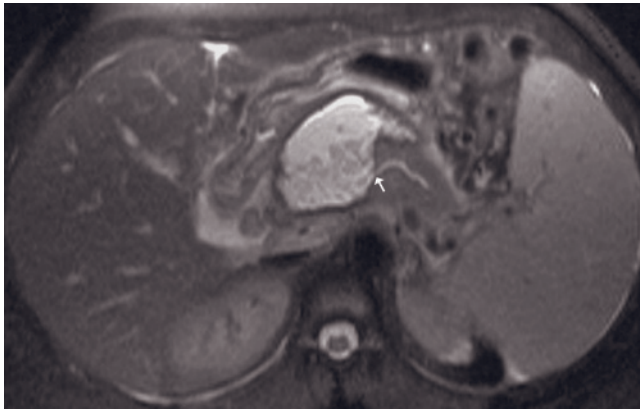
(Continued) An 8-cm pseudocyst is present in the region of the porta hepatis that is mildly high in signal intensity on T1-weighted images (*a, b*) and high in signal intensity on the T2-weighted image (*c*). The mild, high signal intensity on T1-weighted images is more conspicuous with fat suppression (*b*) and consistent with dilute blood or protein. The homogeneous signal intensity on T2-weighted images suggests that the fluid, although proteinaceous, is not complicated by infection or cellular debris. A 3-cm pseudocyst (arrow, *e*) is identified within the body of the pancreas (*e, f*).
